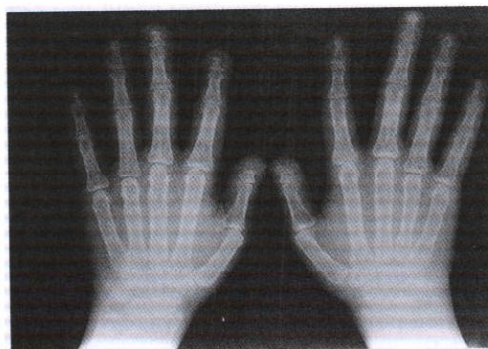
Hand X-ray: shows subperiosteal bone erosions of the phalangeal shafts and erosions of the terminal tufts
